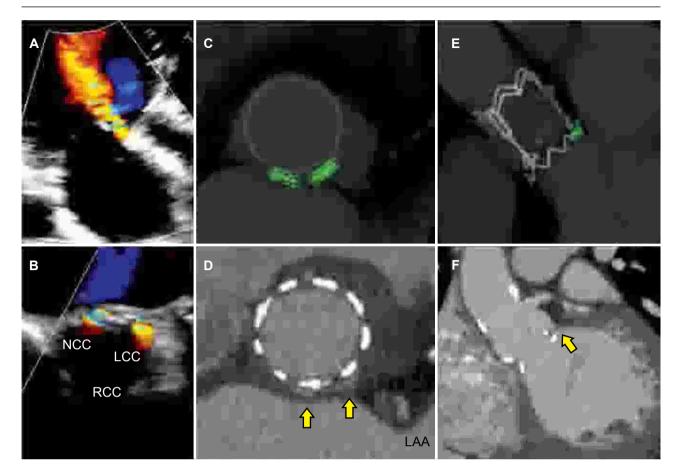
A: Three-chamber transthoracic echocardiogram pre percutaneous closure of a paravalvular leak (PVL), demonstrating severe aortic regurgitation. B: Transoesophageal echo pre percutaneous PVL closure, demonstrating two regurgitant orifices, each 4 mm, adjacent to the non-coronary and left coronary cusps. C: Computed tomography (CT) volume reconstruction, transverse double oblique view. Green dots highlight the orifices of the two paravalvular defects. D: CT, transverse double oblique plane just below the coronary cusps. Yellow arrows highlight the presence of two paraprosthetic defects, the larger adjacent to the left coronary cusp (8×3 mm), and the smaller adjacent to the non-coronary cusp (6×3 mm), in close proximity to first one. E: CT volume reconstruction, coronal oblique view, demonstrating the location of the PVL in relation to the 3f Enable valve. F: CT coronal oblique plane with yellow arrow demonstrating PVL. LCC – left coronary cusp; NCC – non-coronary cusp; RCC – right coronary cusp.
